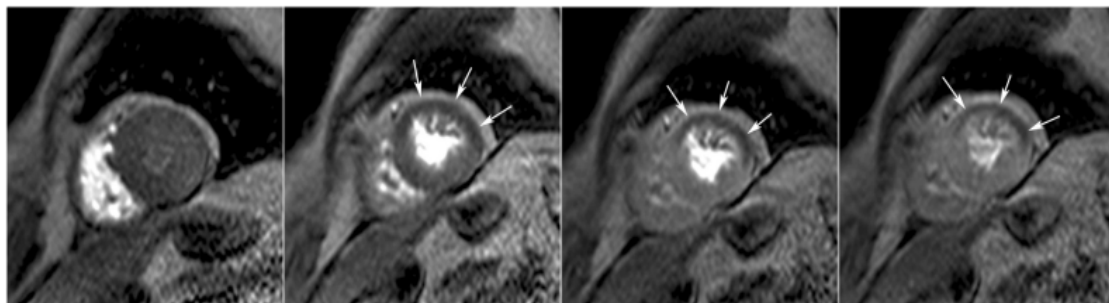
MRI stress perfusion with suspected mid left anterior descending coronary artery (LAD) in-stent stenosis. Midventricular short-axis serial time frames of first pass perfusion during Dipyridamole vasodilatory stress show contrast successively enhancing the right, left chambers and myocardium (images from left to right). A transmural perfusion defect in the anterior and lateral walls is seen (arrows)<sup>19</sup>
